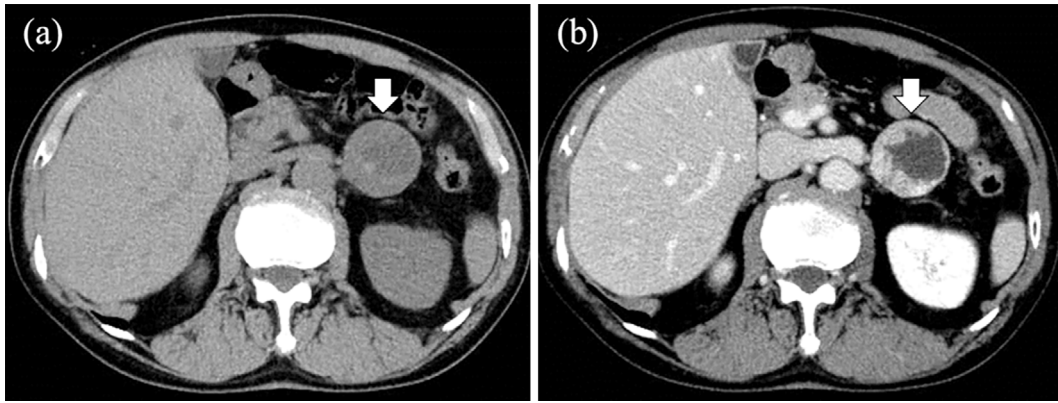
Computed tomography findings. Abdominal plain computed tomography showing a mass measuring 43 mm in diameter in contact with the left adrenal gland (arrow) (a). The margins of the mass were enhanced on contrast; however, the central part was not enhanced, indicating cystic degeneration or necrosis (arrow) (b).
